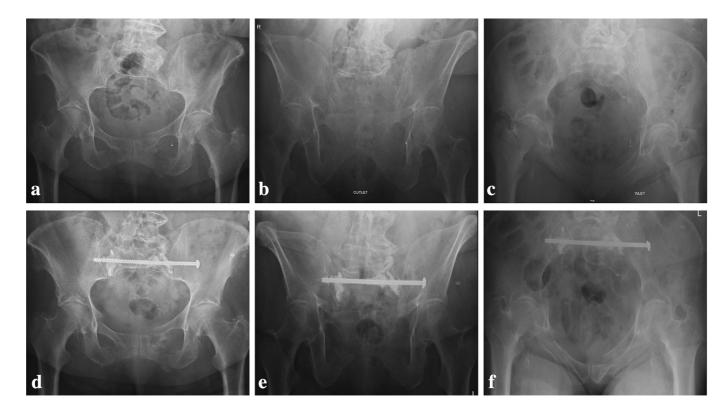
X-ray studies in (a/d) plain anteroposterior, (b/e) outlet, (c/f) inlet projection before and after PMMA augmented transsacral screw fixation. In spinopelvic dissociation, kyphosis of the upper segment results in the "paradoxical inlet" phenomenon of the sacrum in plain anteroposterior radiographs (a). Correction of the sagittal alignment is not possible using transsacral screws and may require LPS. However, when fixation of the status quo seems adequate, one percutaneous in-line PMMA augmented transsacral S1 screw is a valuable alternative and may easily be combined with sacroplasty. The cement sealed fracture gaps without leakage.
